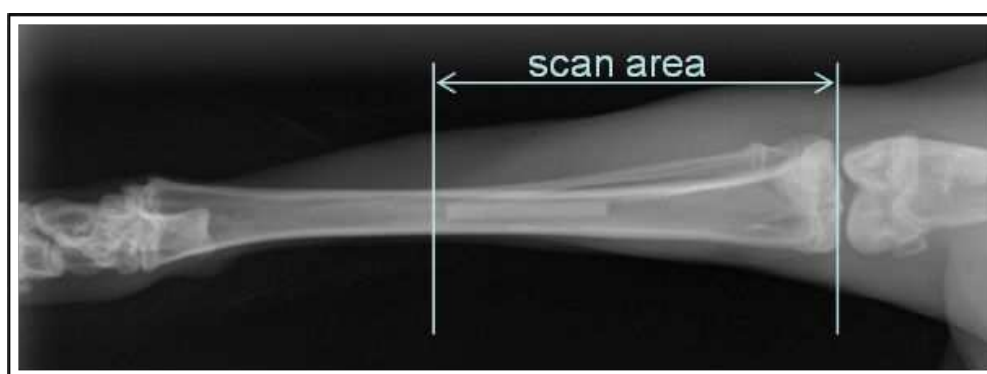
X-ray depiction of an implanted MA-pin with marked μ -CT scan area.
